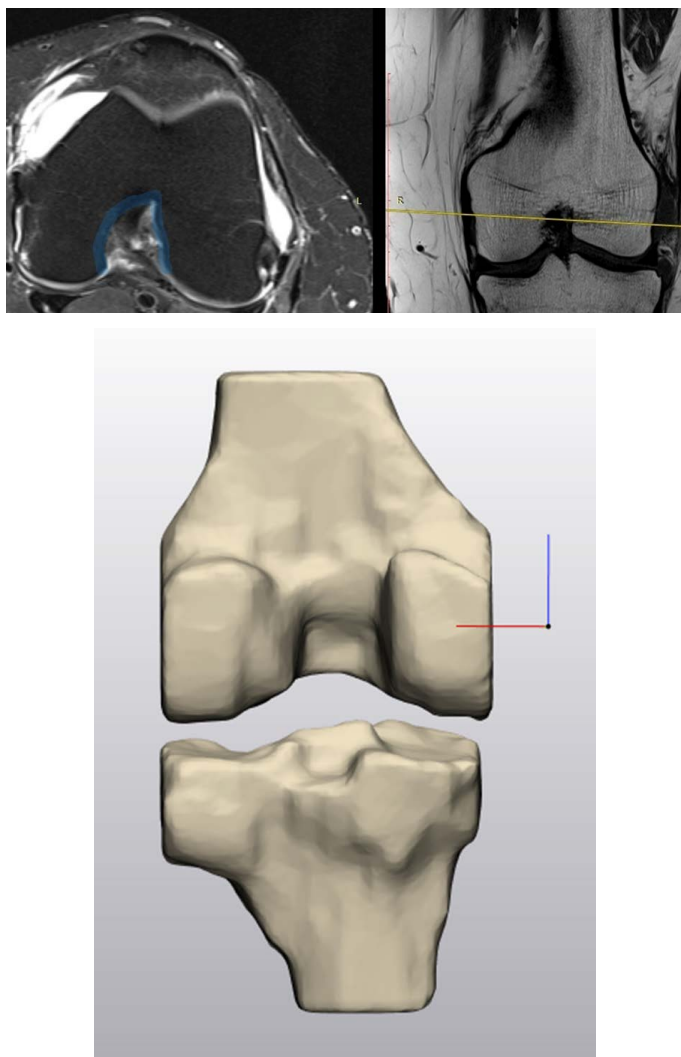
Sagittal and axial 2D and 3D MRI reconstructions demonstrating intercondylar notch morphology types.
